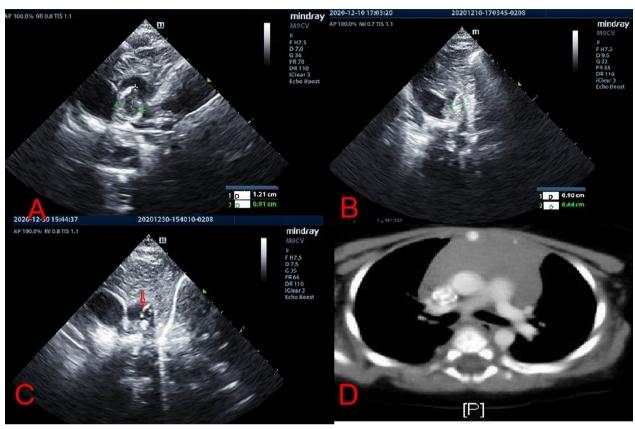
A Echocardiogram showing abnormal echo of the main pulmonary artery, normal internal diameter of the main pulmonary artery, and a hyperecho mass with size of $1.3~\rm cm \times 0.9~\rm cm$ at the distal bifurcation of the main pulmonary artery. B Echocardiogram showing that the thromboembolus was smaller than before $(0.9~\rm cm \times 0.6~\rm cm)$. C Echocardiogram conducted 5 weeks after the identification of a thrombus revealing a main pulmonary artery thromboembolus (red arrow). The external dimensions of the aberrant echogenic mass located at the distal bifurcation measured approximately $1.1~\rm cm \times 0.6~\rm cm$. The core, characterized by hyperechogenicity, had dimensions of roughly $0.5~\rm cm \times 0.4~\rm cm$. D The computed tomography angiogram showed no dilation or filling defect in the pulmonary aortic trunk and pulmonary arteries after $4.5~\rm months$
